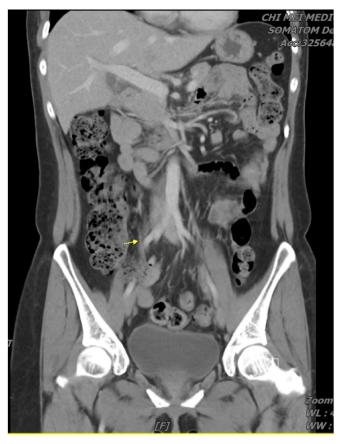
Coronal contrast-enhanced CT demonstrated right ovarian vein (arrows) with resolved thrombus.
